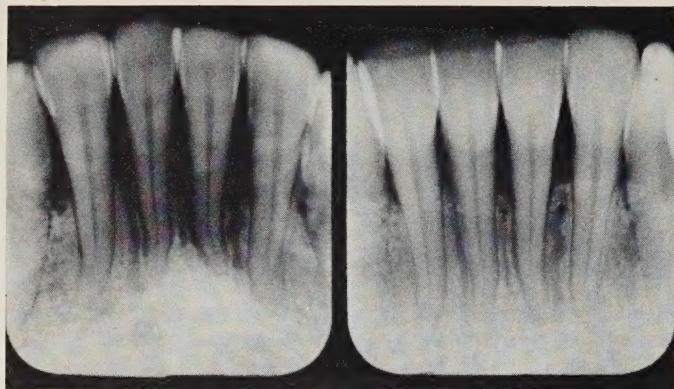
Roentgenographs of mandibular incisor region. Left, Interalveolar bone crests are not recorded on film exposed with 65 Kvp. and 10 ma. Image of teeth and bone is distorted by incorrect film placement and acute vertical angle of projection and film placement with 74 Kvp. and 15 ma. records distinct image of interalveolar crests and a more coronal level of bone than expected from image in A.†
